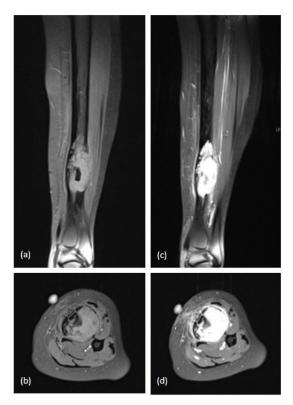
MRI (a) Coronal, (b) axial T1-weighted images showing the lesion at the diaphysis of left distal tibia. MRI (c) Coronal, (d) axial T1-weighted images after gadolinium administration showing intense enhancement of the lesion.
